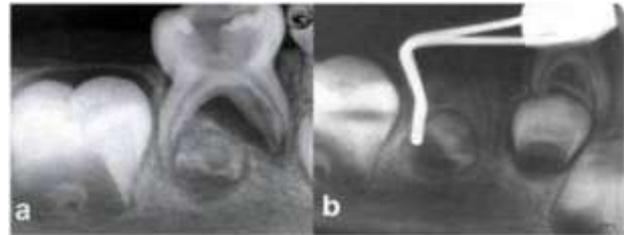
(a) a second primary molar that requires extraction due to periapical bone destruction. (b) distal shoe appliance changed the position of tooth #20 bud.
